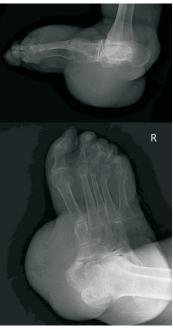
Preoperative radiographs of rheumatoid-associated peri-talar subluxation and giant synovial cyst.
